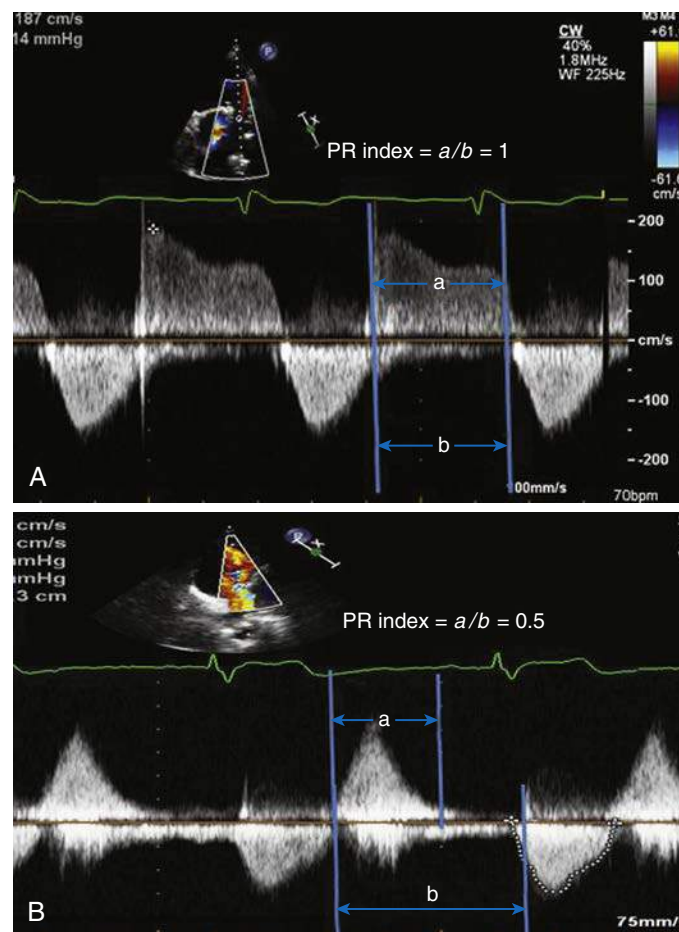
Imaging from a patient with repaired tetralogy of Fallot (TOF). Continuous-wave (CW) Doppler recording of flow across a pulmonary valve shows (A) mild PR (performance index [PI] index = 1) and (B) severe PR (PI index = 0.5). PR, Pulmonary regurgitation.
